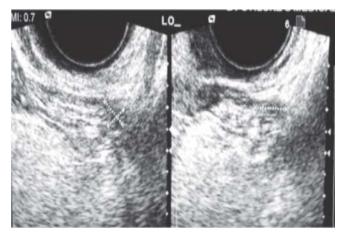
Transvaginal ultrasound showing measurement of the left gonad. The left gonad measured 0.7cm x 0.9cm x 0.6cm. It is devoid of follicles.
